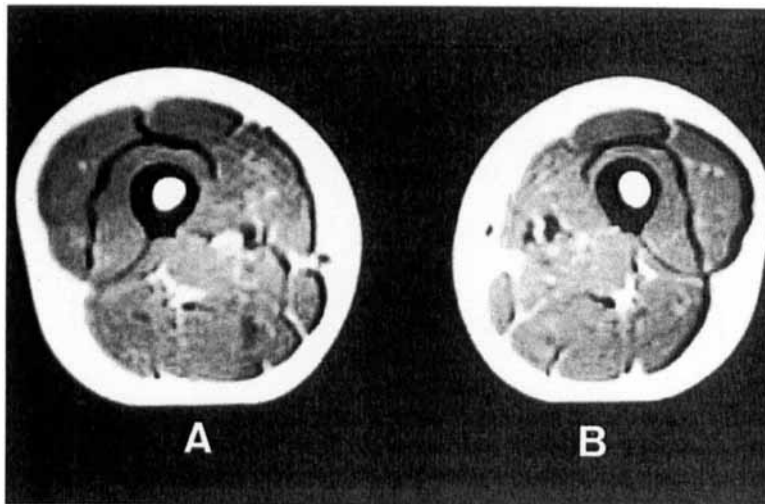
$^1\text{H}$ -MR image of bilateral thighs 10 cm proximal to the patellar upper margin in a spin-echo technique with a repetition time of 2,000 ms and an echo time of 28 ms showing the markedly reduced cross-sectional area of the quadriceps muscles on the injured side (B) compared with those on the noninjured side (A).
